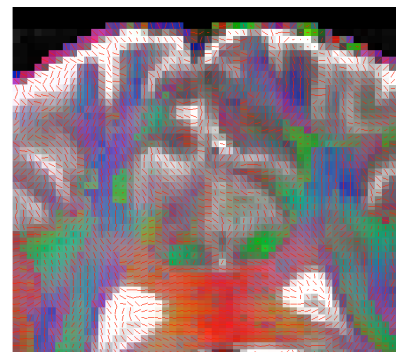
Combined diffusion directions, FA overlaid on T2-weighted image
